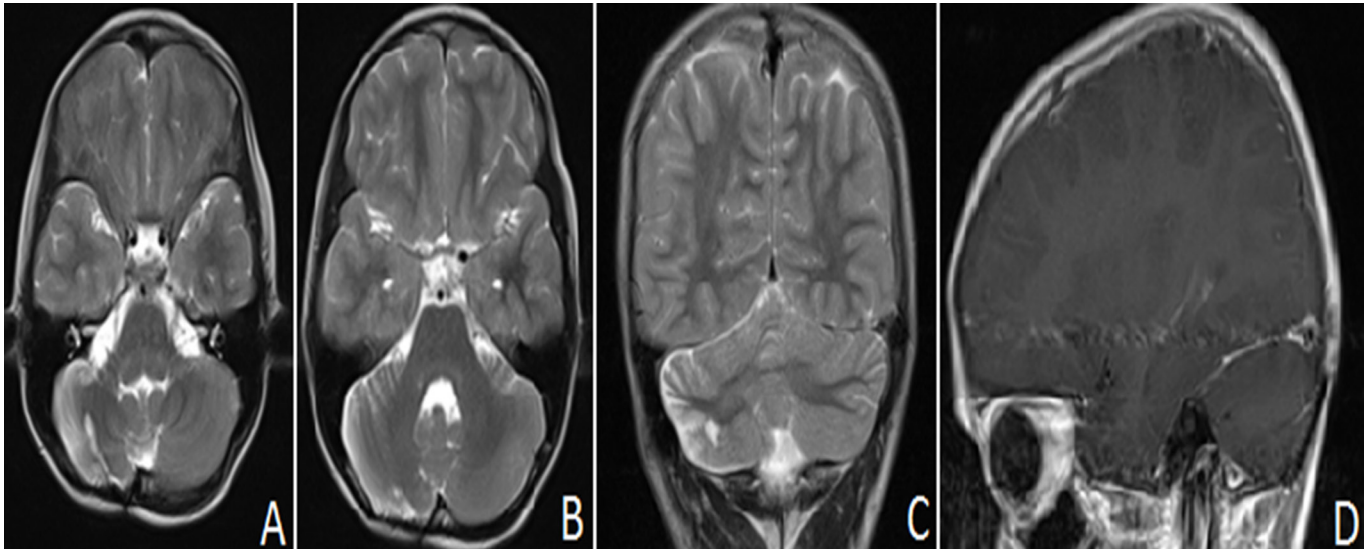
A-B-C; T2 MR images in the axial and coronal plane at the 1st month of postoperatif, D ;contrast MRI imaging in the sagittal plane.
